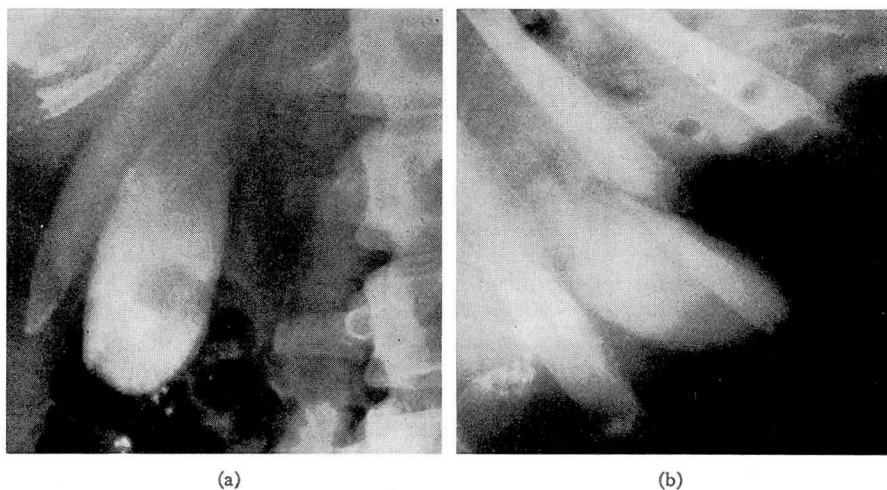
Normal gallbladder. (a) Posteroanterior prone roentgenogram showing fundus of the gallbladder obscured by gas and fecal shadows in hepatic flexure of the colon. (b) Posteroanterior lateral decubitus roentgenogram revealing that gallbladder has dropped toward the right and now lies unobscured by gas.
